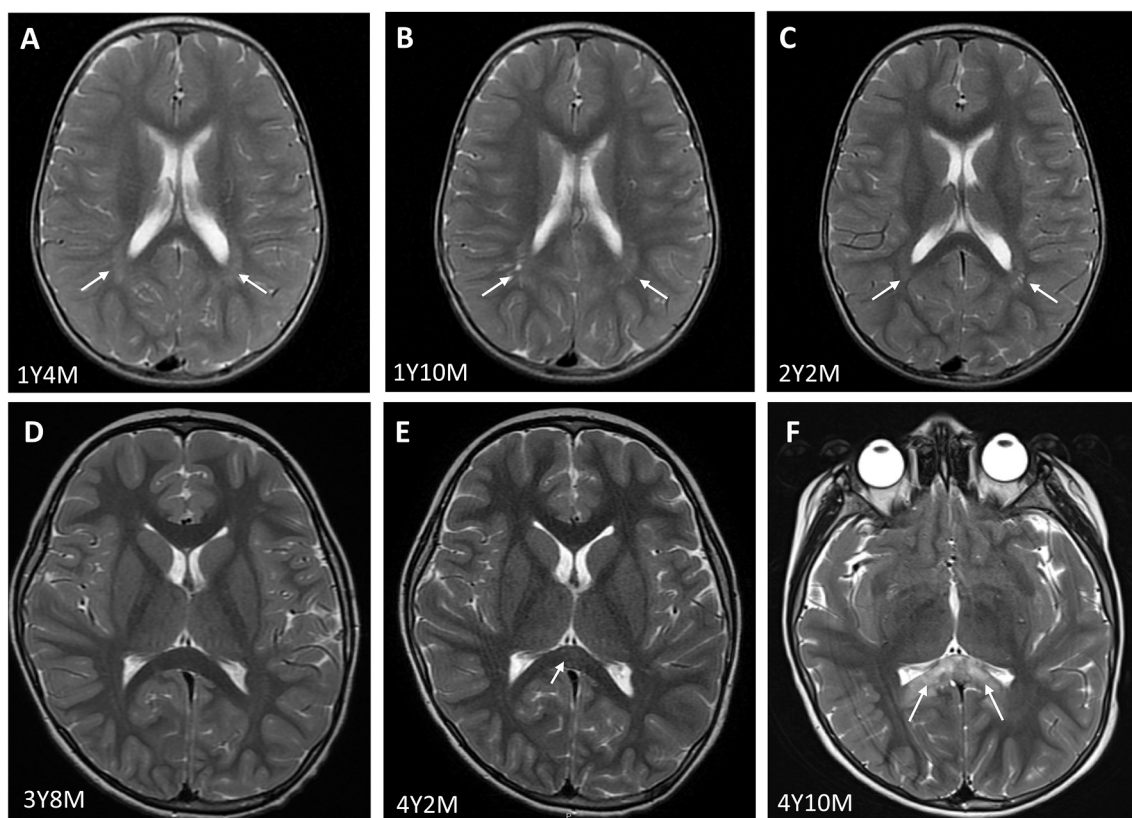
Brain MRI images of two adrenoleukodystrophy patients. Serial MRI scans for patient 1 (A–C). Normal appearance of MRI at 1 year and 4 months old (A). Follow-up MRI at the age of 1 year 10 months showed a suspicious T2 hyperintensity at right parietal white matter (B). However, 3 months later there was no progression of MRI findings (C). Serial MRI scans for patient 2 (D–F). Normal appearance of MRI at 3 year and 8 months old (D). Follow-up MRI performed at the age of 4 years 2 months was initially reported as normal, but the T2 abnormality at the splenium was already present (E). Follow-up scans revealed rapid progression of splenium T2-hyperintensity (F).
